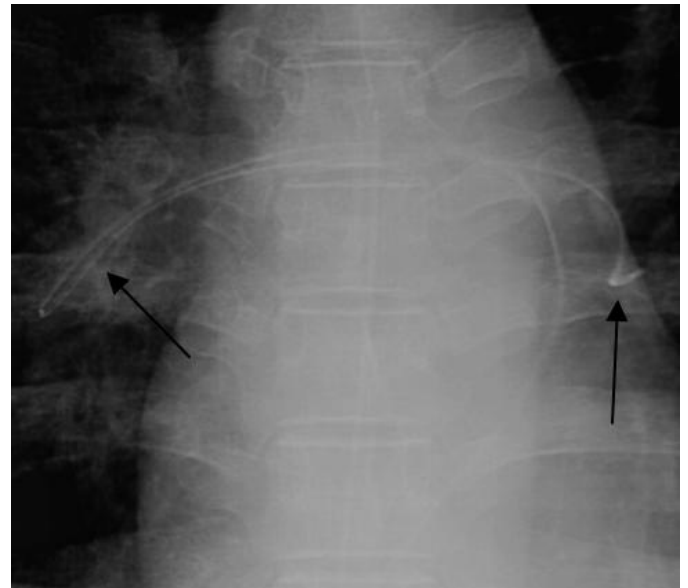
Frontal chest radiograph demonstrating an embolized PICC line in the pulmonary artery (arrows).
